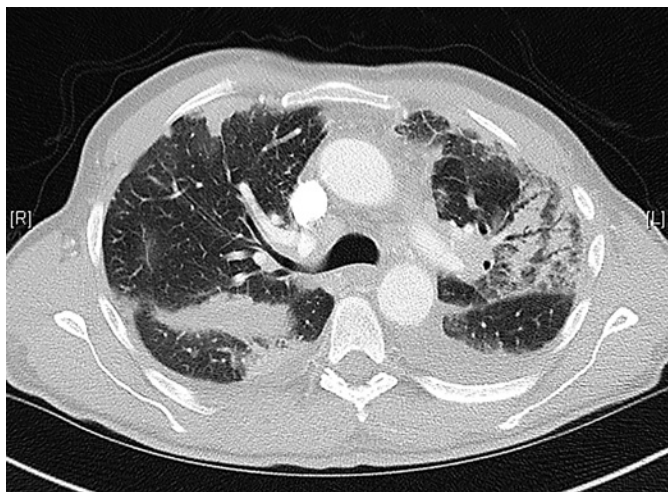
Chest CT in a patient with eosinophilic granulomatosis with polyangiitis. Areas of consolidation, ground glass opacity, and air bronchogram correspond to eosinophilic pneumonia. Pleural effusion related to cardiac failure is also visible.
